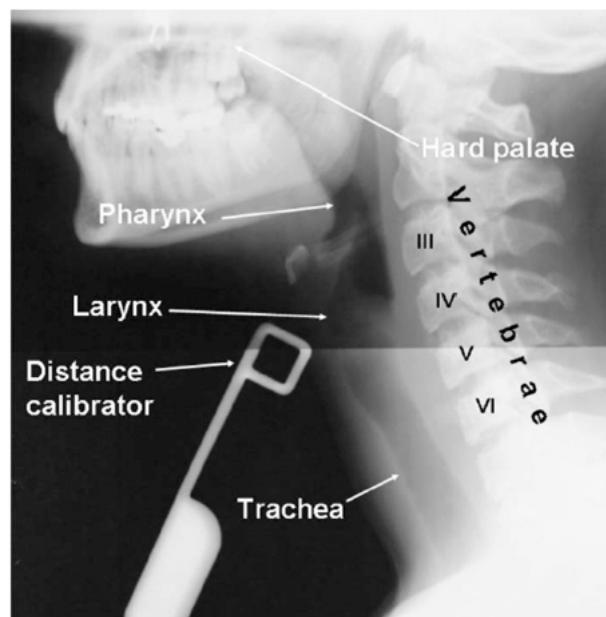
An example of an image of the vocal tract obtained using X-ray imaging (from [88]).
